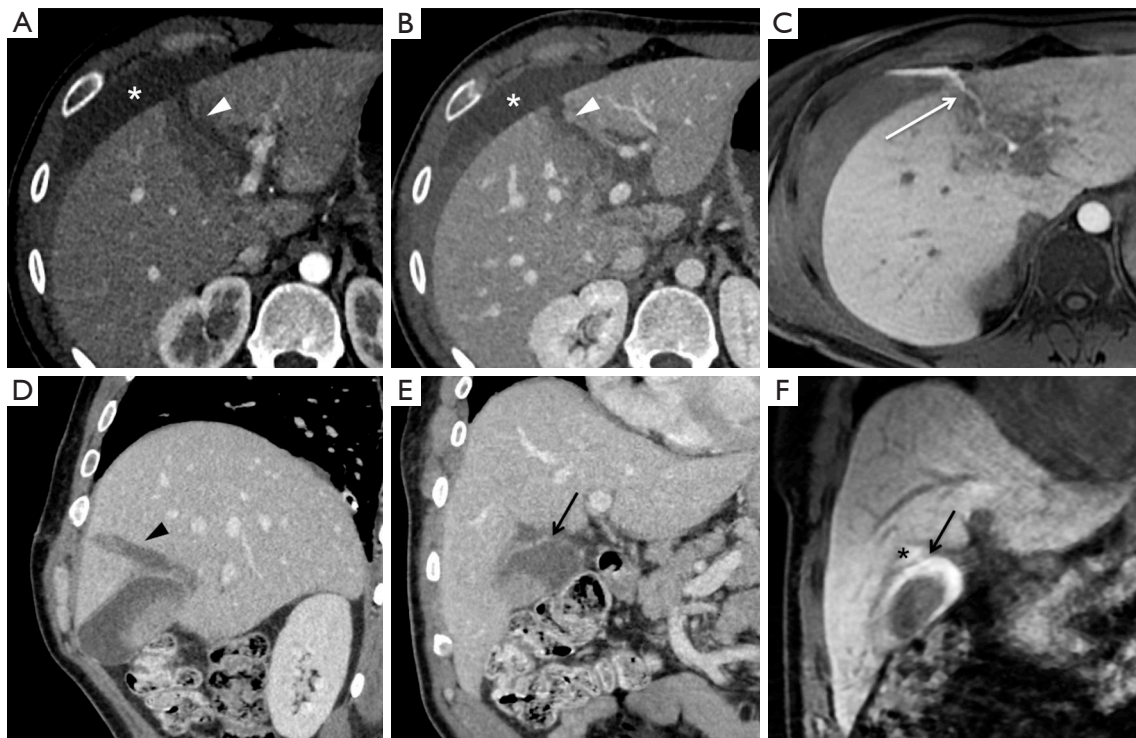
Examples of extrahepatic biliary leak after abdominal trauma. Upper row: extrahepatic biliary leak in a 34-year-old woman referred to an ED after abdominal blunt trauma from an accidental fall from a bicycle. Arterial (A) and portal (B) phases at admission CT scan showed IV segment liver laceration (white arrowheads) with hemoperitoneum (white asterisk) but no active bleeding. Control liver MRI performed 14 days after trauma showed perihepatic fluid collection associated with a biliary leak (white arrow) at hepatobiliary phase scan acquired after 30 minutes from gadoxetate disodium contrast agent administration (C). Bottom row: extrahepatic biliary leak in a 54-year-old man referred to an ED after perforating abdominal trauma from an accidental fall from a tree (penetrating trauma from a 15-cm-long wooden tree branch). Sagittal (D) and coronal (E) portal phase CT scan reconstruction at admission showed penetrating liver injury (black arrowhead) resulting in gallbladder wall perforation (black arrow). Subsequent MRI hepatobiliary phase scan acquired after 30 minutes from gadoxetate disodium contrast agent administration (F) confirmed gallbladder wall laceration (black arrow) and associated biliary leak (black asterisk). ED, emergency department; CT, computed tomography; MRI, magnetic resonance imaging.
